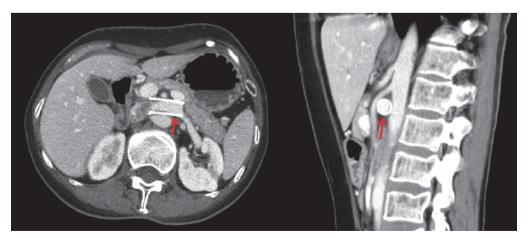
CT showed the stent in the left renal vein.
